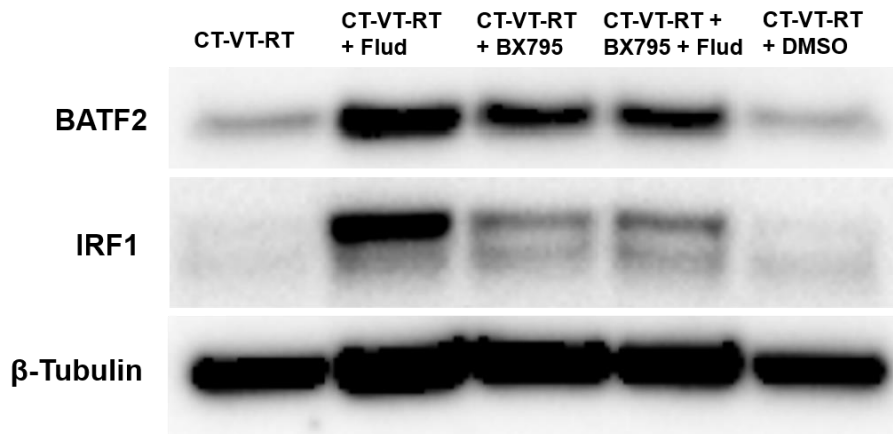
Inhibition of type 1 interferon response pathway post CT-VT-RT results in synchronous increase of BATF2 and IRF1 protein. Immunoblot analysis revealed increased in BATF2 protein expression (upper panel) in IFN- β -STAT1 inhibited samples with maximal expression after treatment with CT-VT-RT + fludarabine. Corresponding increase in IRF1 expression (middle panel) and β -tubulin (lower panel) was used as loading control.
